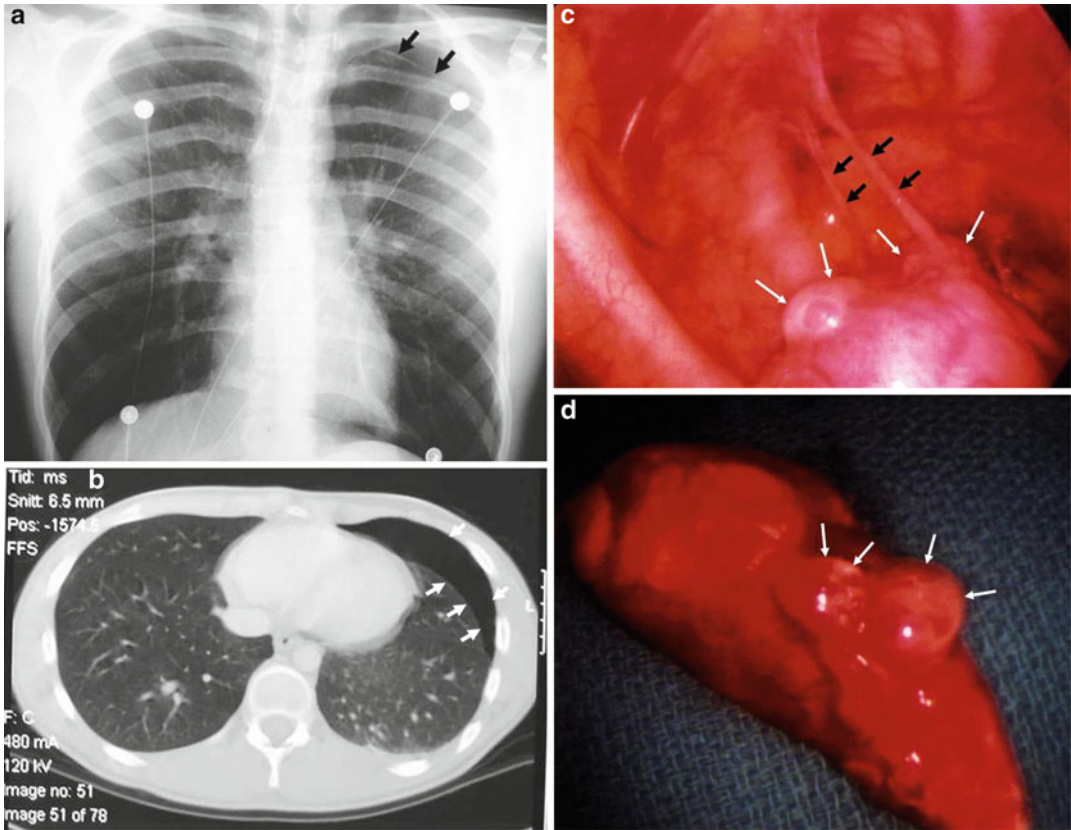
(a–d) A 20-year-old male with Marfan syndrome with repeat spontaneous pneumothorax from ruptures of apical blebs. The chest X-ray shows collapsed left lung with pleural line (*arrows*). The CT of the chest shows pneumothorax on the right lung (*arrows*). Thoracoscope image from the right lung shows two bands representing
